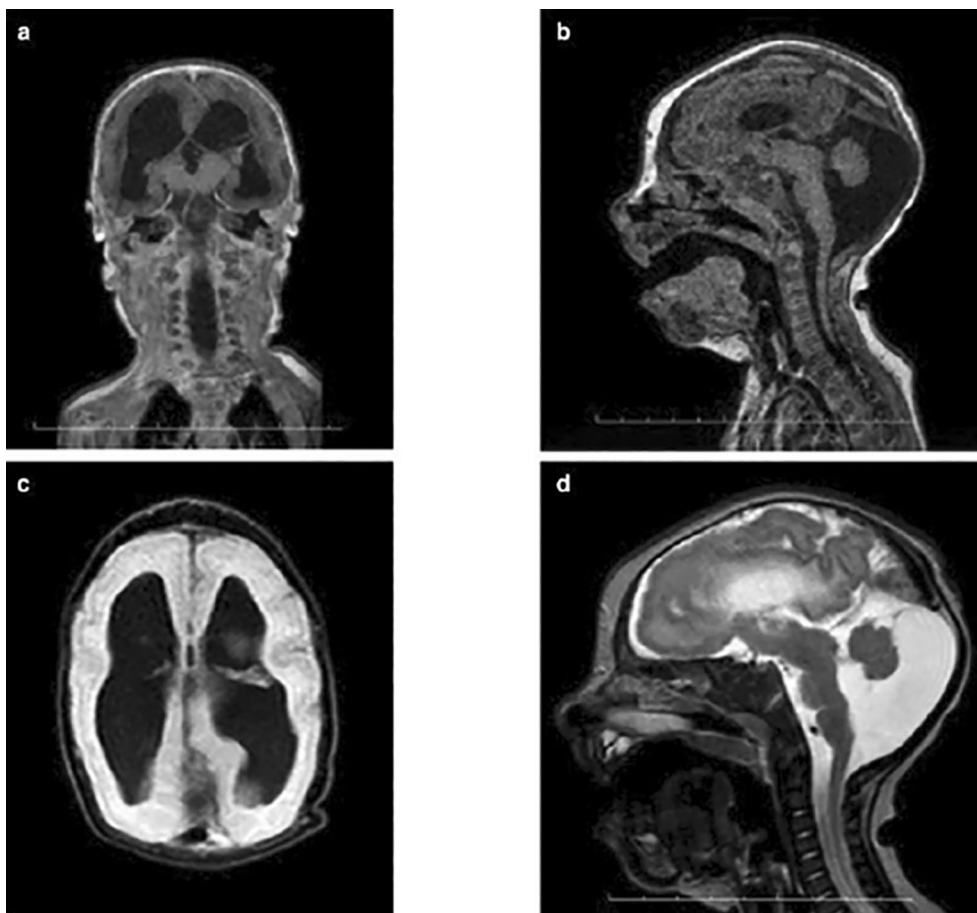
An infant has been diagnosed with congenital Zika virus infection, which has resulted in widespread cortical atrophy and underdevelopment of the corpus callosum, cerebellum, and brainstem. The results are shown by a coronal fluid-attenuated T2, sagittal fluid-attenuated T2, axial fat-saturated T1, and sagittal T2 weighted MRI.
